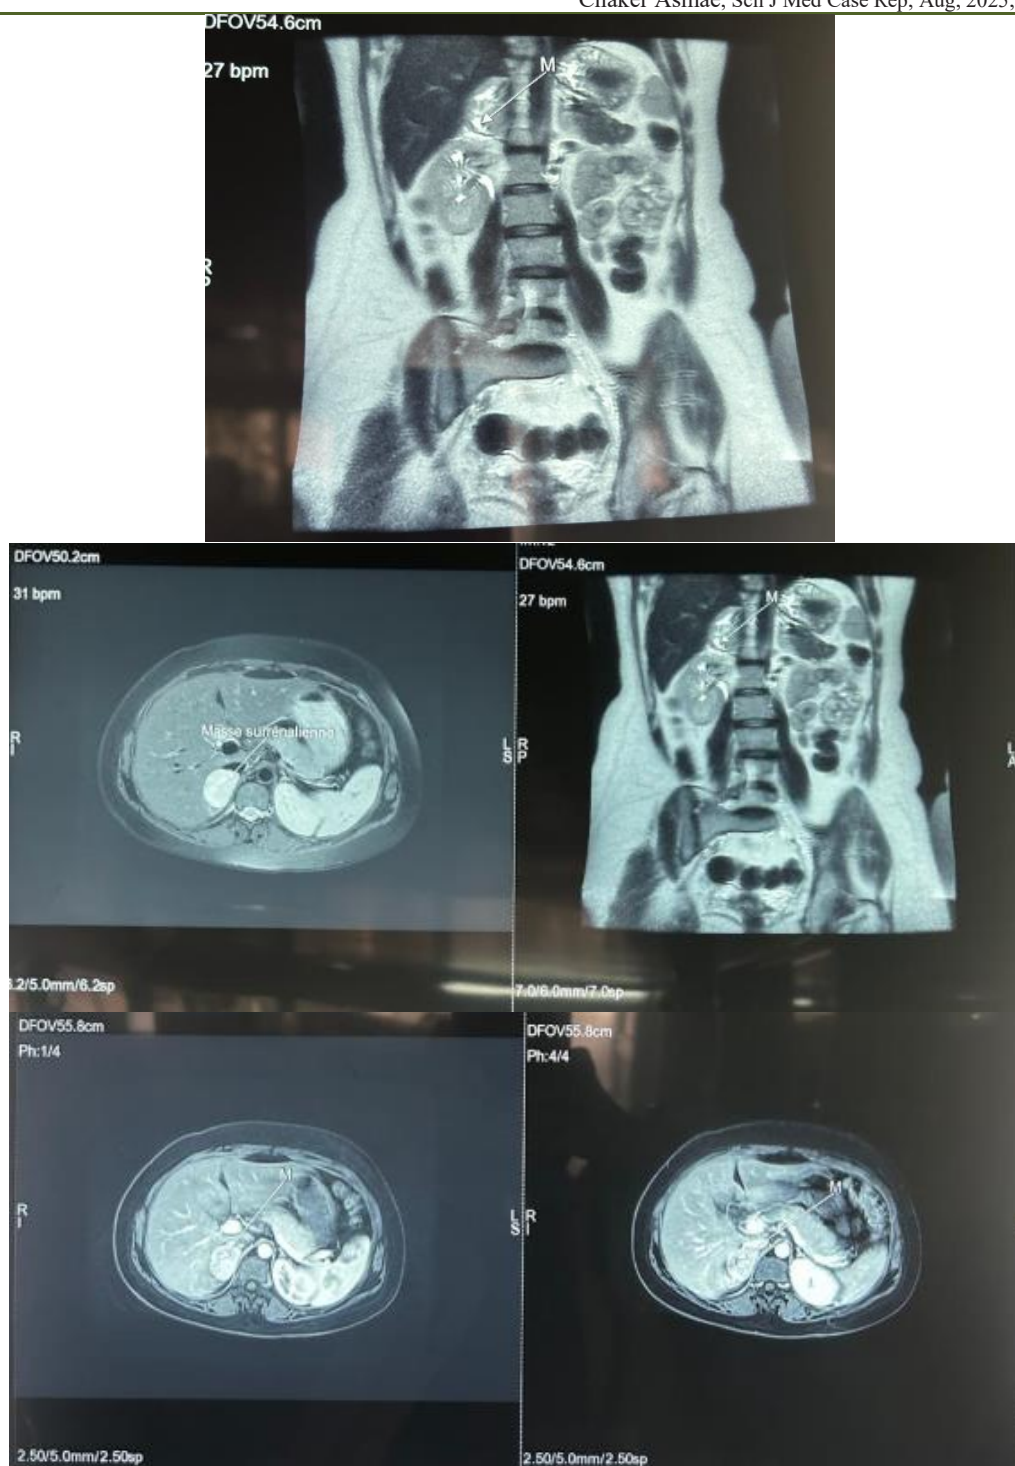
MRI of the abdomen showing a left adrenal mass consistent with pheochromocytoma
